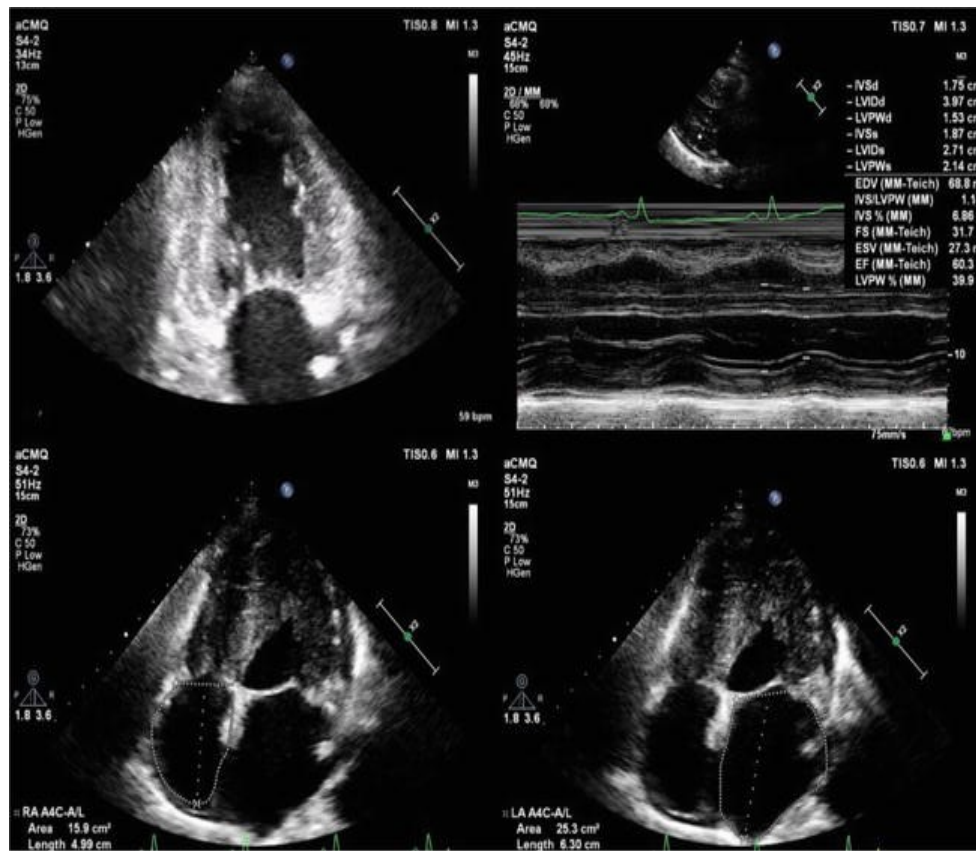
2D echocardiogram (apical 2 chamber view, M-mode in parasternal long axis view and apical 4 chamber view) in a patient with AL type showing increased thickness of the left ventricular walls, biatrial dilatation and hypertrophic interatrial septum.
